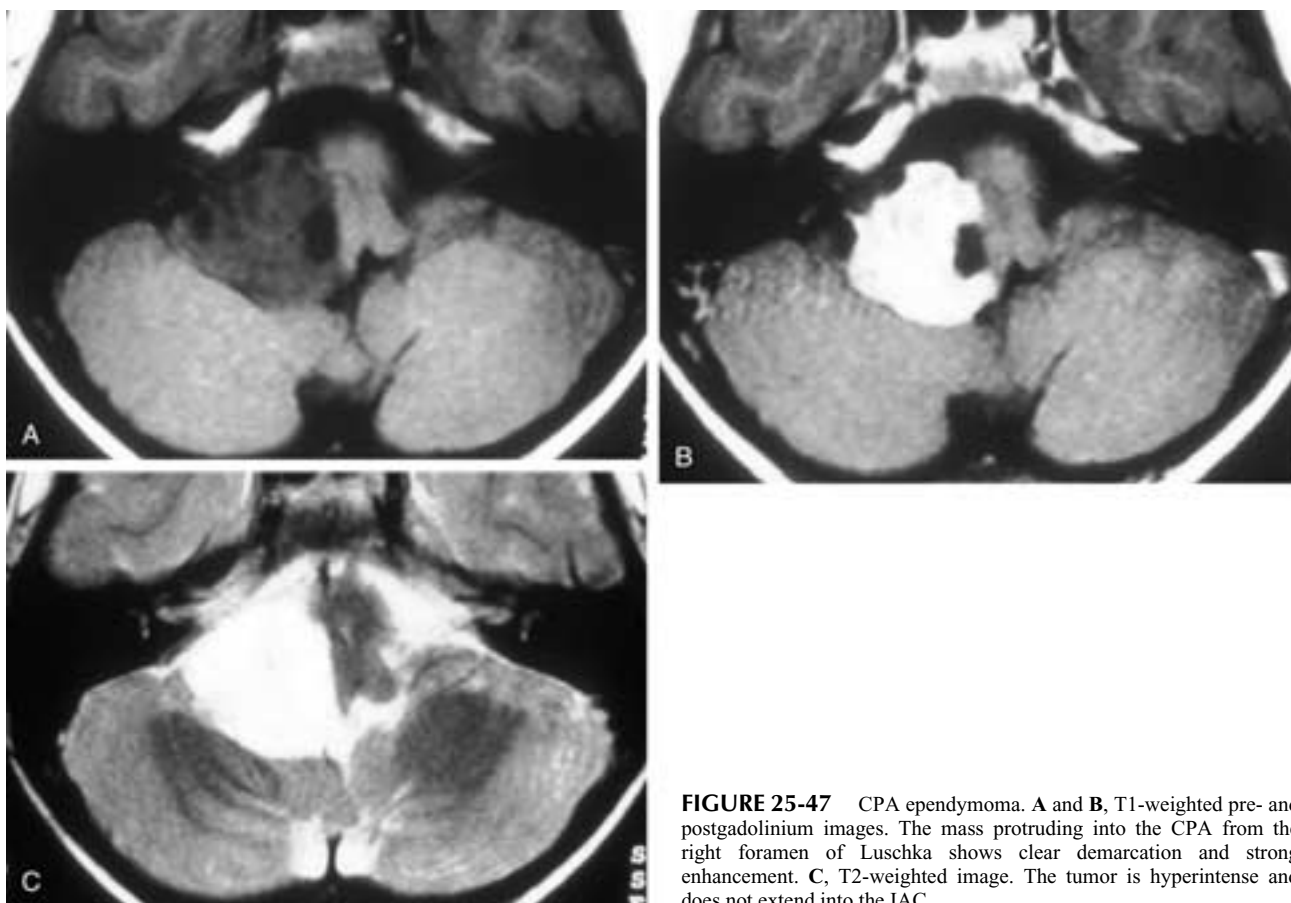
CPA endypymoma. A and B, T1-weighted pre- and postgadolinium images. The mass protruding into the CPA from the right foramen of Luschka shows clear demarcation and strong enhancement. C, T2-weighted image. The tumor is hyperintense and does not extend into the IAC.
